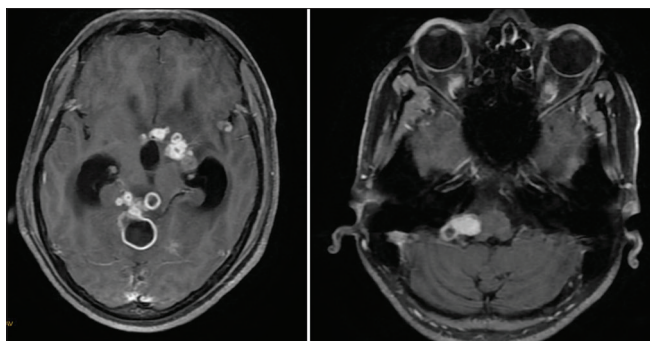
Post-contrast fat-saturated T1-weighted magnetic resonance images showing multiple intra-axial as well as extra-axial peripherally enhancing lesions involving brainstem, left temporal region, ambient cistern, and cerebellopontine angle in known case of central nervous system tuberculosis
